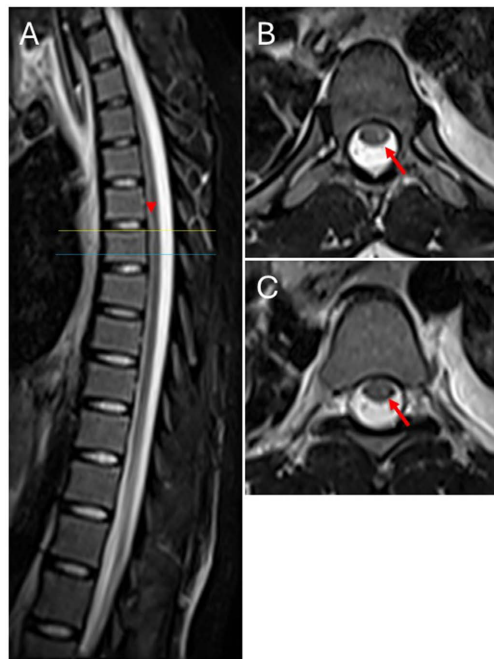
T2 hyperintensities in the thoracic spine on MRI. A, Sagittal T2 sequence showing subtle T2 hyperintensity of the anterior spinal cord (arrowhead). (B) and (C), Axial T2 sequences at the levels of the yellow (B) and blue (C) dotted lines show areas of T2 hyperintensity in the left hemicord (arrows).
